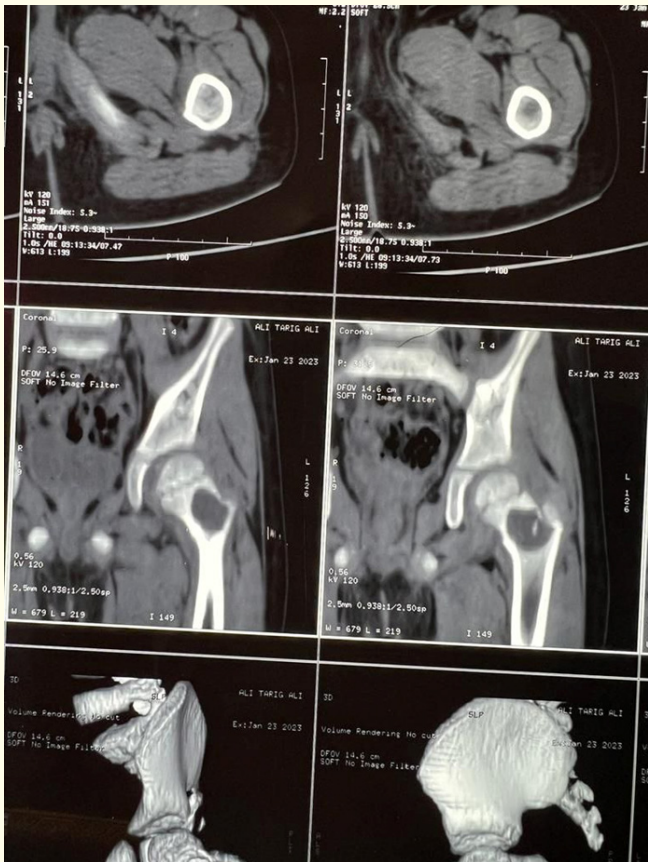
CT scan shows cystic lesion and fallen leaf sign.
